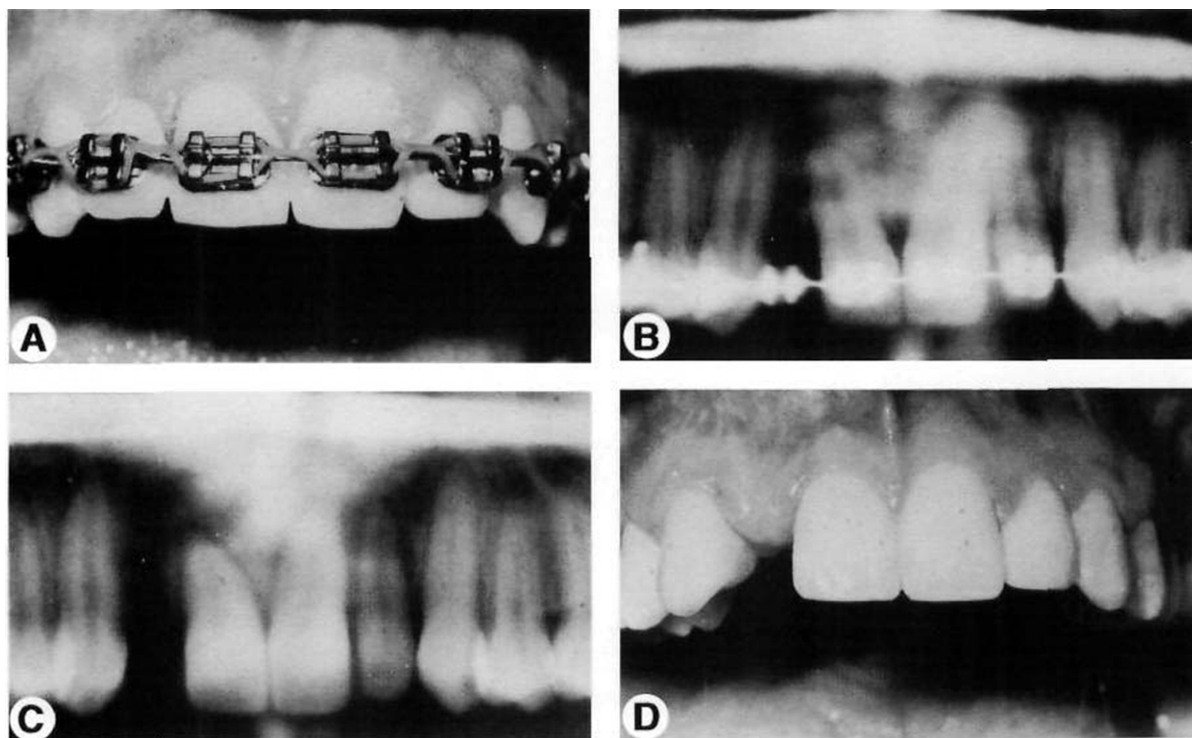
This patient is congenitally missing the maxillary right lateral incisor (A). An implant was planned for this space, however a radiograph before finishing showed that the roots were in close proximity (B). An additional 6 months of orthodontics was required to correct root angulation (C and D). Evaluation of periapical radiographs before bracket removal is important in patients who will require single-tooth implants.
